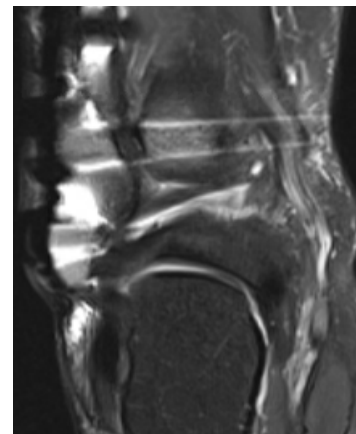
MRI was limited due to metal artifact, but ongoing healing was confirmed given lack of fracture gap formation and remodeling at site of bone graft placement
